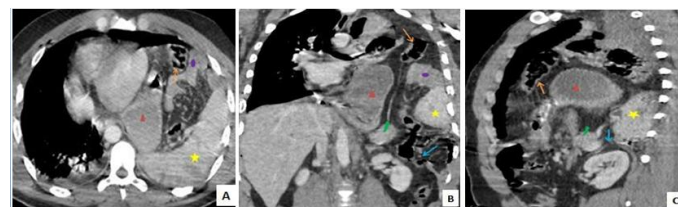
Thoracoabdominal CT scan in axial (A), coronal (B) and sagittal (C) sections showing a large left diaphragmatic rupture (blue arrow) with herniation of the stomach (▲), left colon (orange arrow), tail of the pancreas (♣), and spleen (★) producing the "viscera-dependent" sign, associated with a homolateral haemothorax (●).
